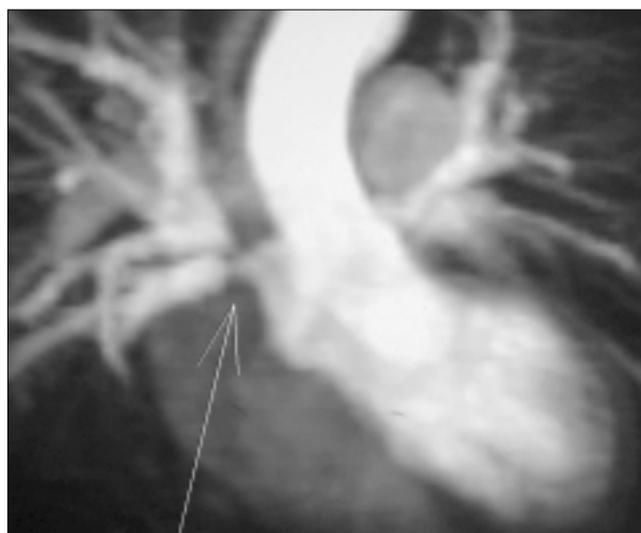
Magnetic resonance imaging with Gadolinium showing tight stenosis of the confluence of the right-sided pulmonary veins (arrow).
